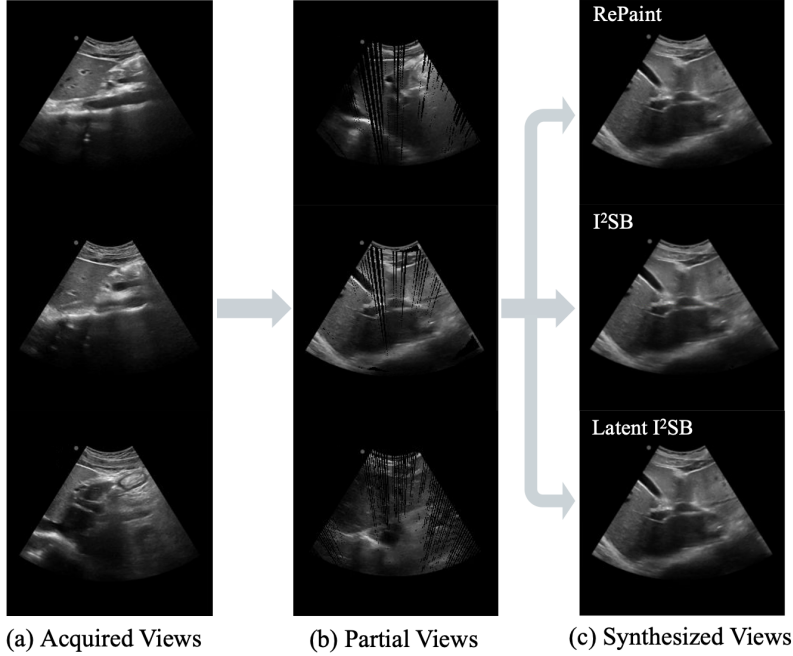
Novel-view ultrasound synthesis results. (a) Acquired views from sparse freehand scanning. (b) Random partial views rendered from the point-cloud representation, showing missing regions prior to completion. (c) Synthesized views produced by RePaint,  $I^2SB$ , and latent  $I^2SB$ .
